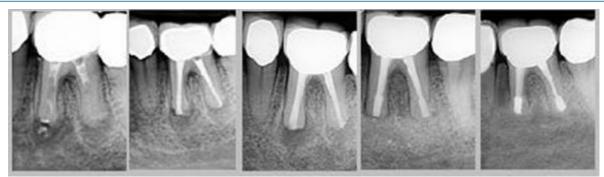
Periapical surgery on tooth #36 after 2 years of monitoring of the orthograde retreatment.
